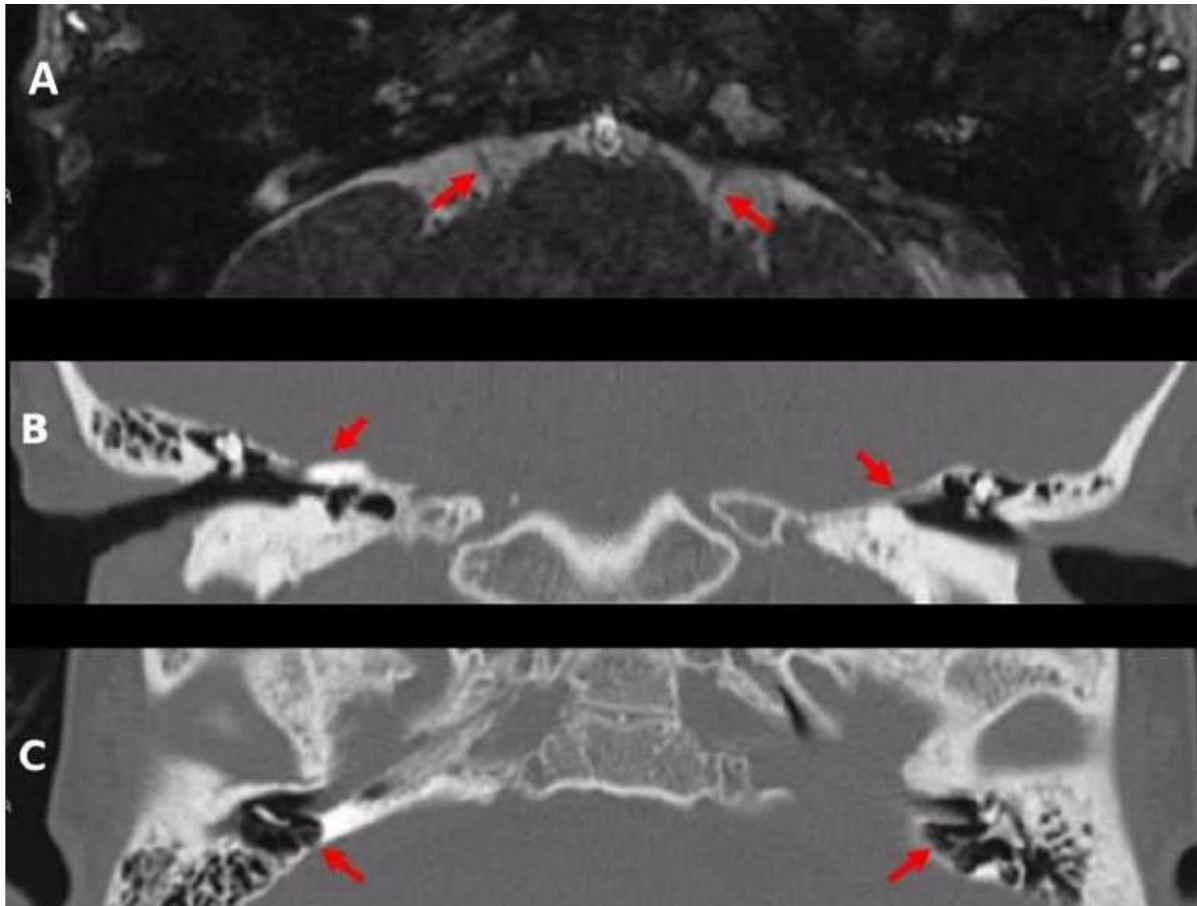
CT and MRI revealing an incomplete partition type II in a patient affected by CHARGE association.
